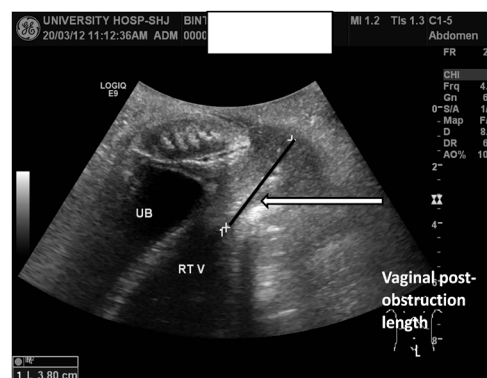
Trans-perineal ultrasound showing the distance of the distal vaginal obstruction from labia major 'long arrow'.
